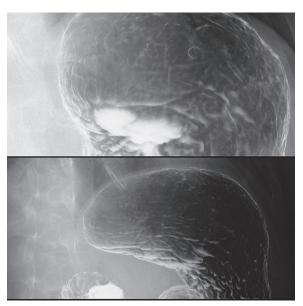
X-ray Findings Are a Clear Circumference but Partially Unclear Border, Indicating the Tumor Has a Gentle Border Partly Like SMT
